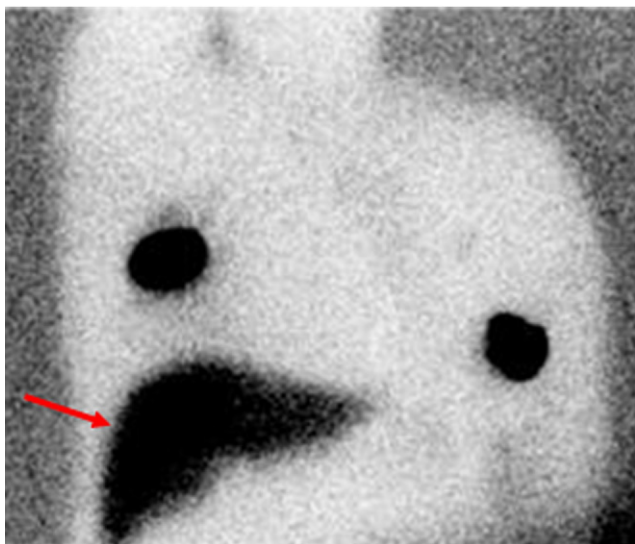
Bilateral lymphoscintigraphy with $^{99\text{m}}\text{Tc}$ -SC: One of the injections infiltrated the venous system causing reticuloendothelial uptake generally seen in a liver-spleen scan. (Color version of figure is available online.)
